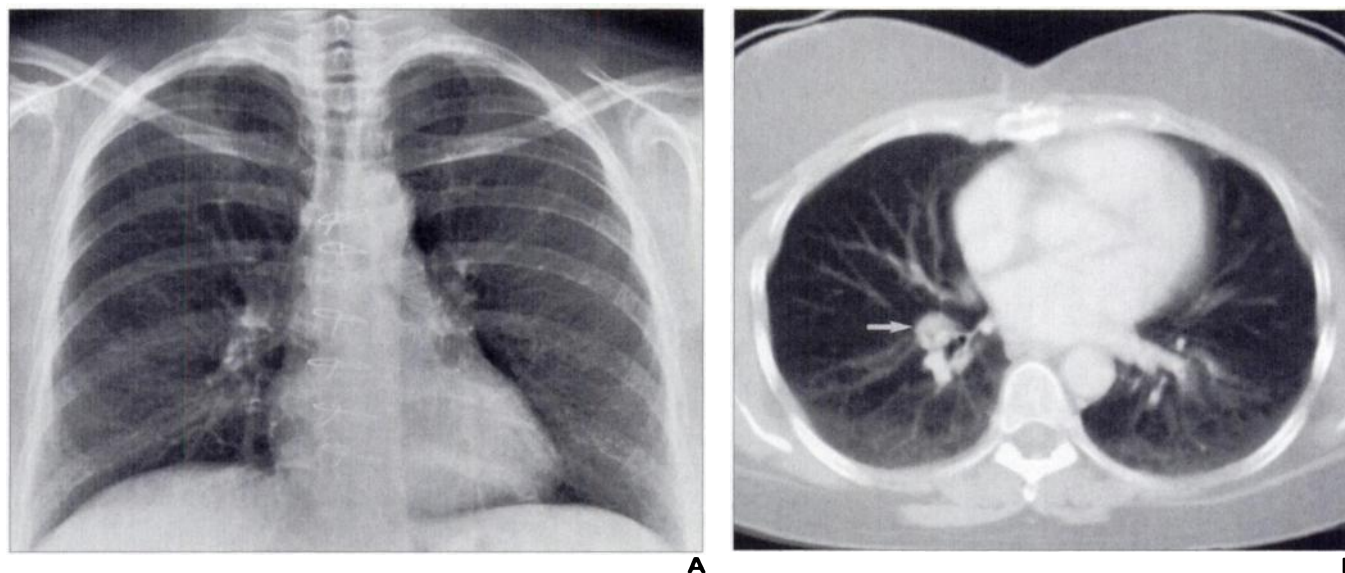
54-year-old man with primary lung carcinoma found on CT who had negative chest radiograph.
